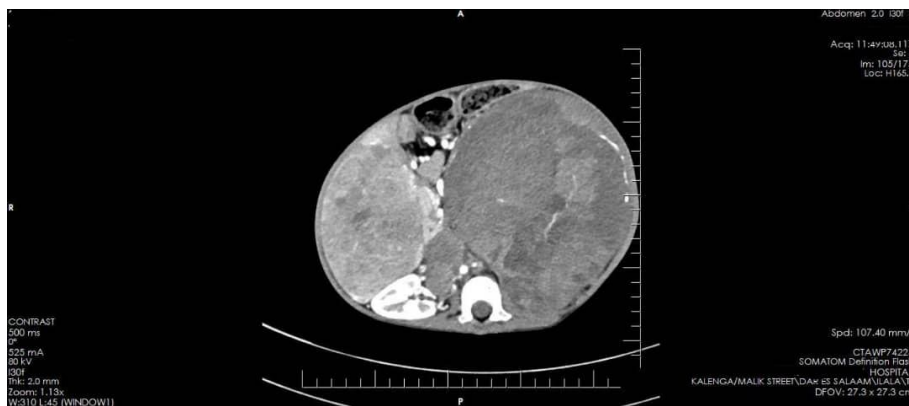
Contrast-enhanced CT revealed a large lesion measuring approximately 56 x 58 mm with central areas of necrosis and surrounding solid areas involving the inferior and mid poles of the left kidney
